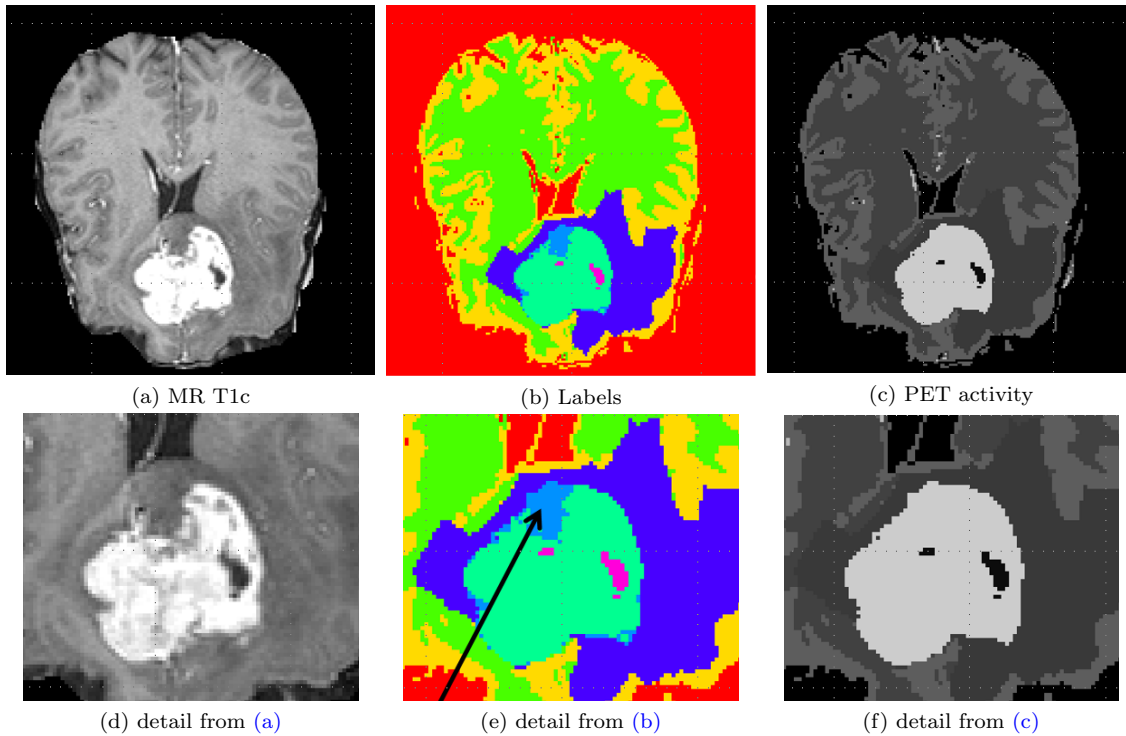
From the BRATS database, T1c MR image (a),(d), label image available from the database (b),(e), generated dynamic PET activity image (c),(f). The black arrow in (e) highlights the non-enhancing (MR) label which represents PET/MR mismatch.
